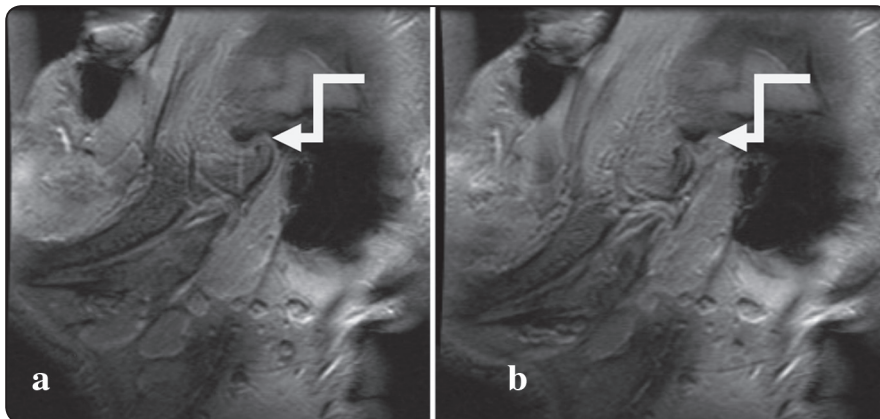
Postoperative Dynamic MRI views (one month) showing recapture disc position over the condyle in a) closed mouth position b) opened mouth position (white arrows)
